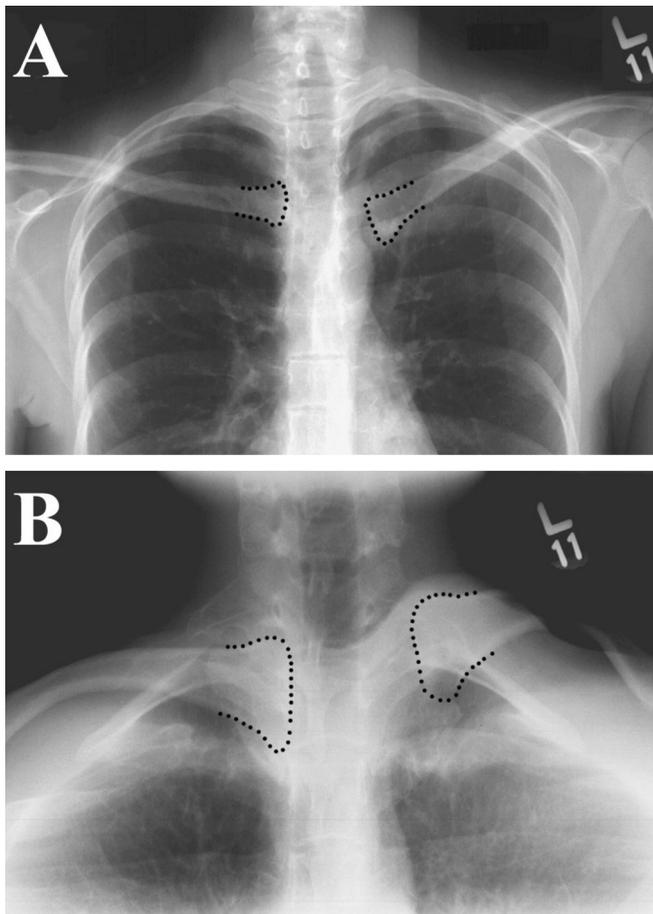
Preoperative (A) anteroposterior and (B) serendipity (Rockwood) radiographs demonstrating asymmetry and anterior dislocation of the left sternoclavicular joint.
